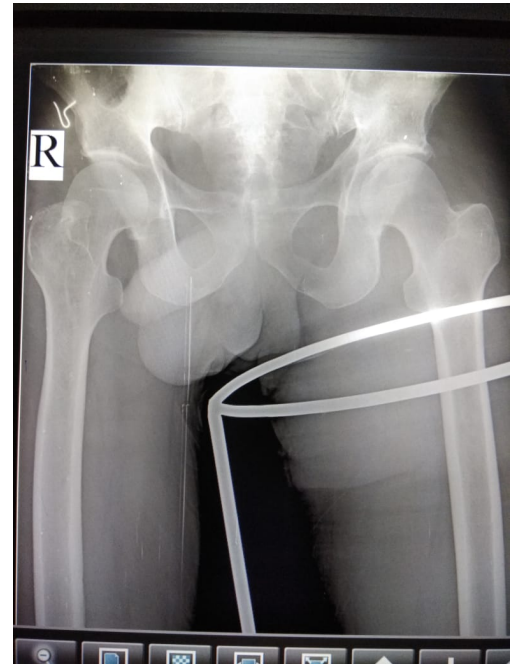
X-ray pelvis with bilateral hip joint showing reduced left hip joint with Thomas splint *in situ* (post-reduction).
